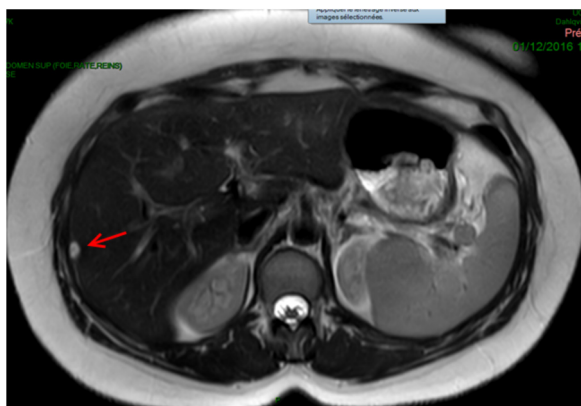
Liver lesion segment VI; MRI T2- weighted images.
